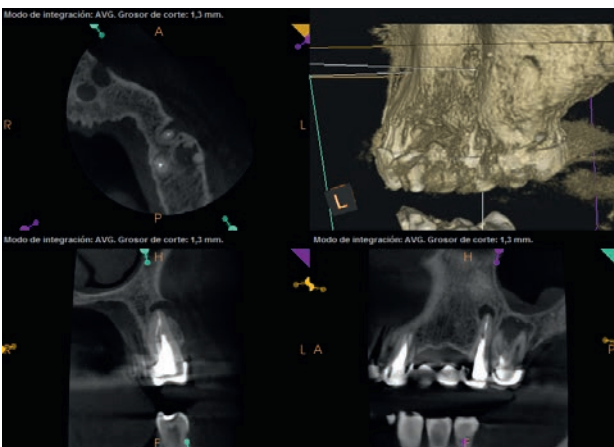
Upper left second premolar and first molar preoperative CBCT image.
